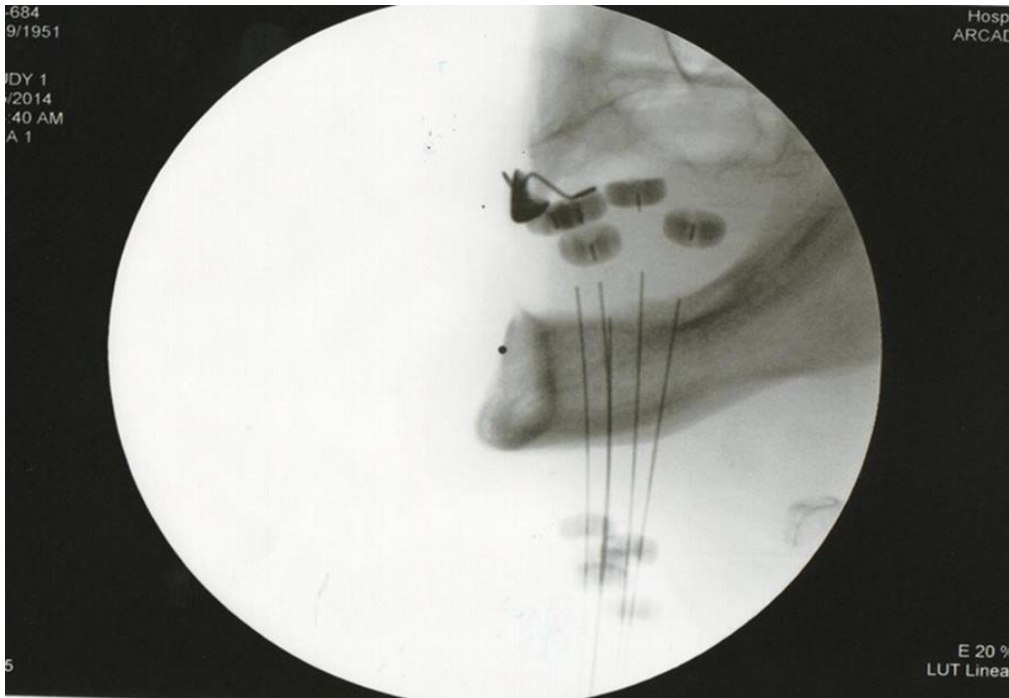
Lateral X-ray of 5 implanted flexible plastic catheters with markers and fixation plastic buttons (Ferenczi Ö., 2021)
